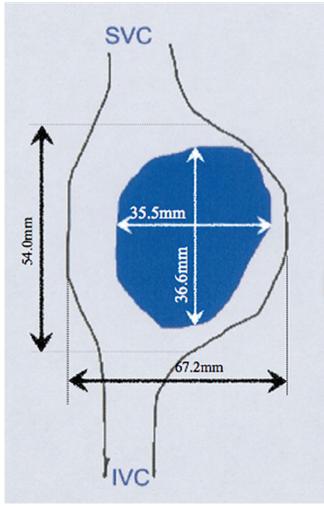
Transthoracic echocardiography findings of atrial septal defect (ASD). The ASD occupies large part of the atrial septum. SVC = Superior vena cava; IVC = Inferior vena cava.
